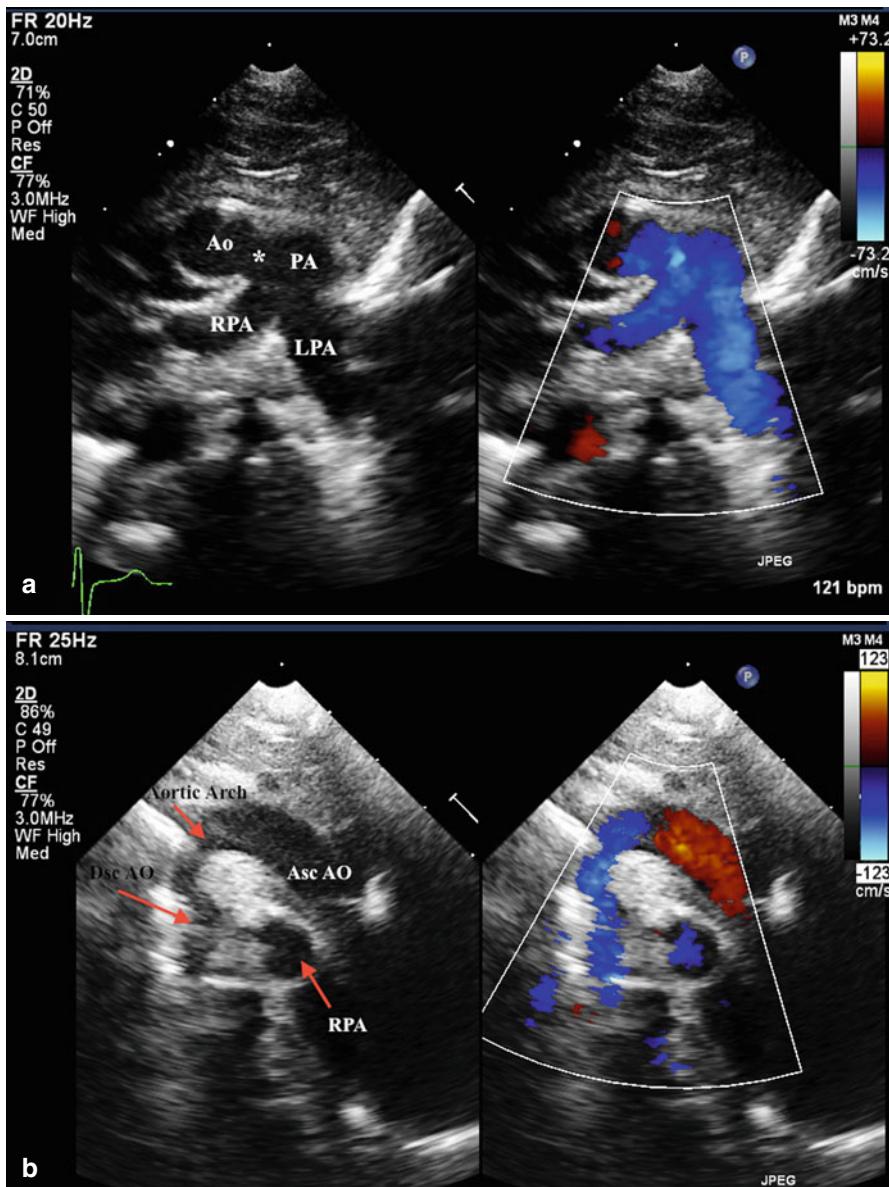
(a) 2D echocardiogram and colour Doppler imaging of a high parasternal short-axis view with colour Doppler showing the aortopulmonary window (*) between the ascending aorta (Ao) and main pulmonary artery (PA). *RPA* right pulmonary artery; *LPA* left pulmonary artery. (b) 2D echocardiogram and colour Doppler imaging of a suprasternal long axis of a right aortic arch with inadequate view of the aortic arch branching pattern. *Asc Ao* ascending aorta; *Dsc AO* descending aorta; *RPA* right pulmonary artery
